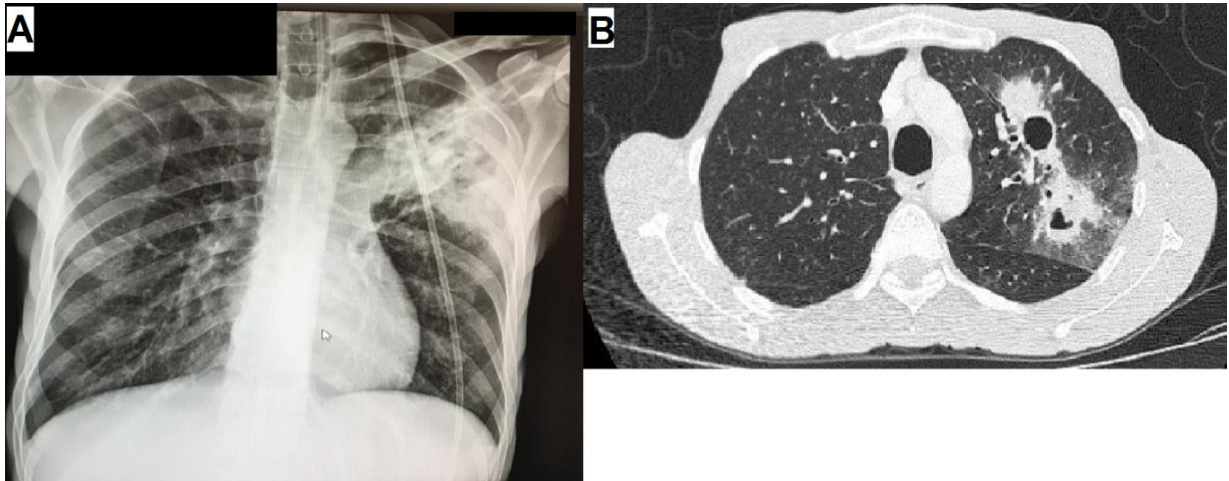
A. Chest radiograph (May 2017, Day 0) showing bilateral ground-glass pattern and left upper lobe bronchiectasis. B. Chest computed tomography shows consolidation area in the left upper lobe with two cavities, the largest 4 cm, and bronchiectatic areas, ground glass attenuation areas and septal thickening.
